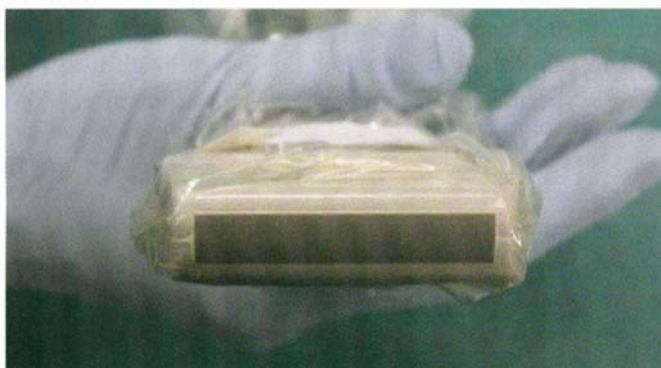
The active area of the ultrasound probe with the sterile probe cover. It is important to avoid any creases in order to maintain optimal image quality which is easily possible with this system.
